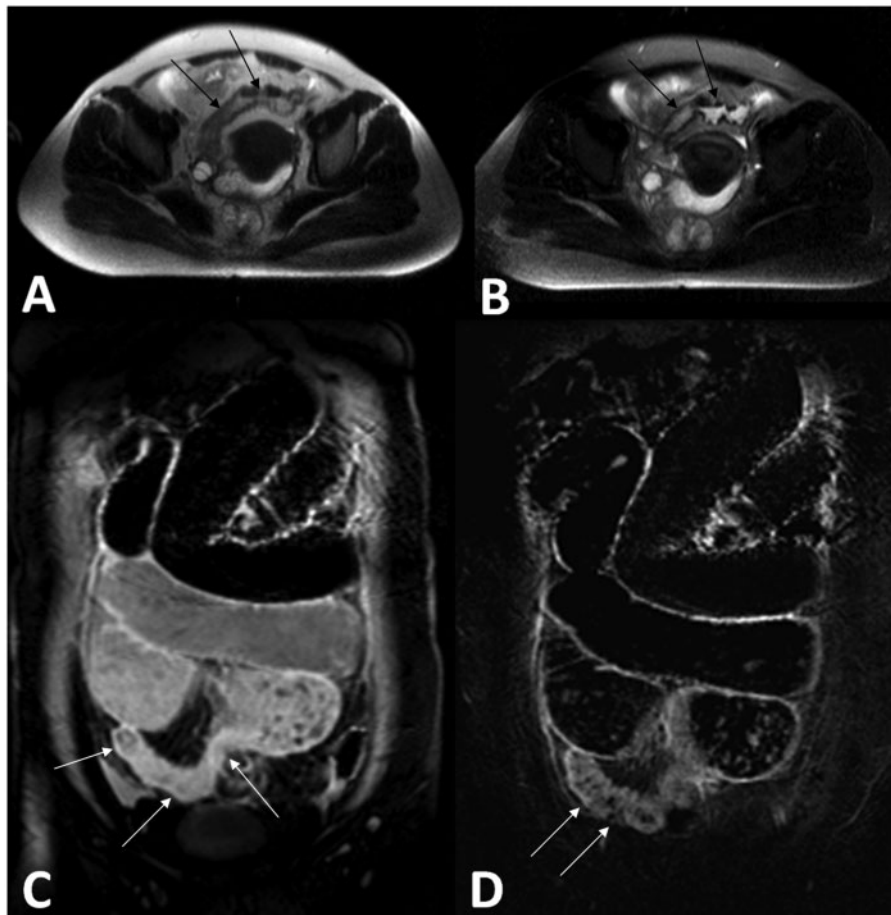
Case 4. Axial non-fat-saturated (A) and fat-saturated (B) HASTE images of the patient demonstrate bowel wall thickening and luminal narrowing in the distal ileum (arrows in A and B). Coronal post-contrast T1W MRI with fat saturation (C) and subtracted (D) images show mesenteric stranding, luminal narrowing and contrast material enhanced mucosa in the terminal ileum (arrows).
